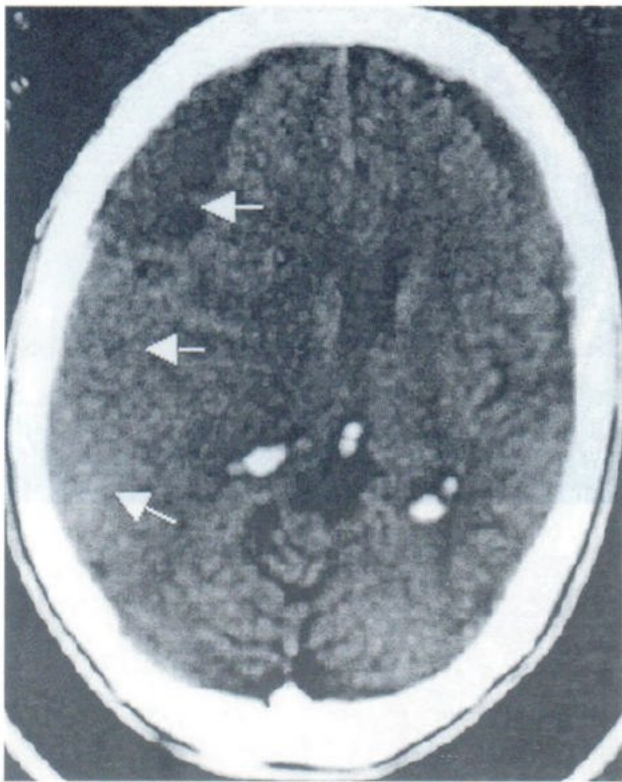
A Subdural hematoma CT before contrast media injection.
